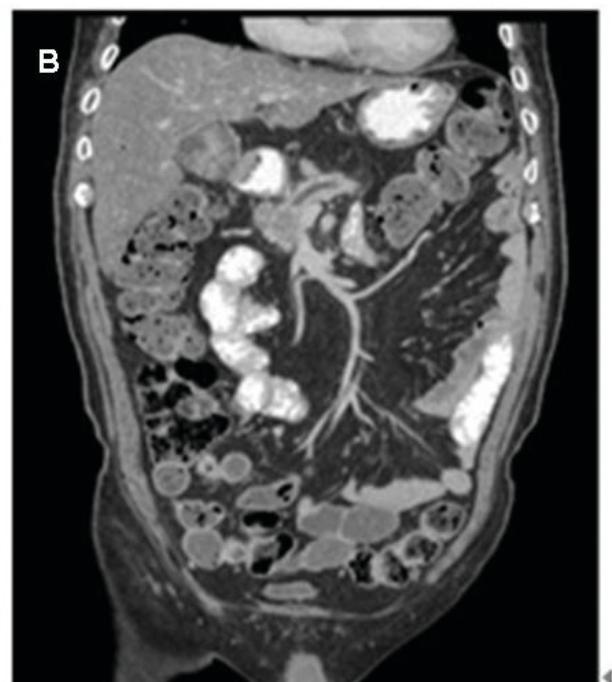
The preoperative CT findings. A. A liver mass (2.8cm) in the right lobe segment 7. B. GB cancer and pancreas head cancer (2.7cm) with pancreatic duct dilatation.
